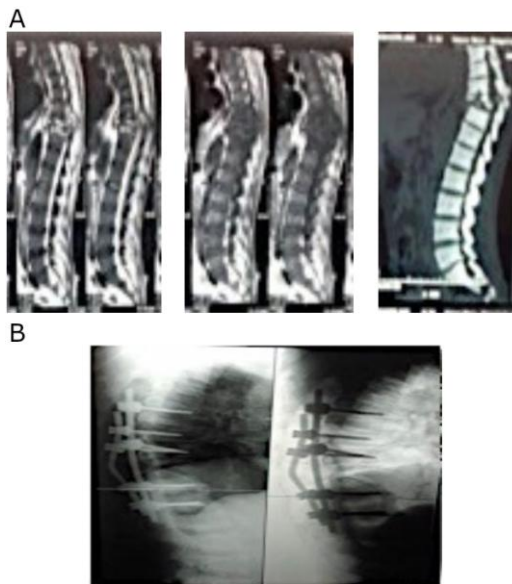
A) Preoperative Sagittal T1WI, Axial T1WI and Sagittal T1WI with contrast; B) Postoperative Plain X-ray Lateral and Axial views
